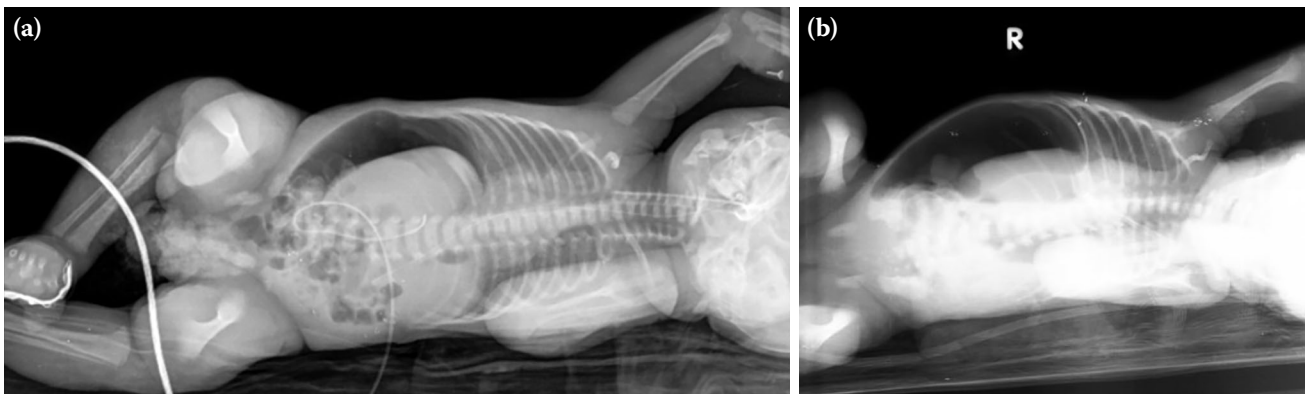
If subdiaphragmatic air is suspected in the standing X-ray, cross table lateral graph taken with the patient lying on the left lateral side, and the air accumulated between the liver and the abdominal wall can be demonstrated in babies with excessively dilated intestines. (a) First case. (b) Third case.
